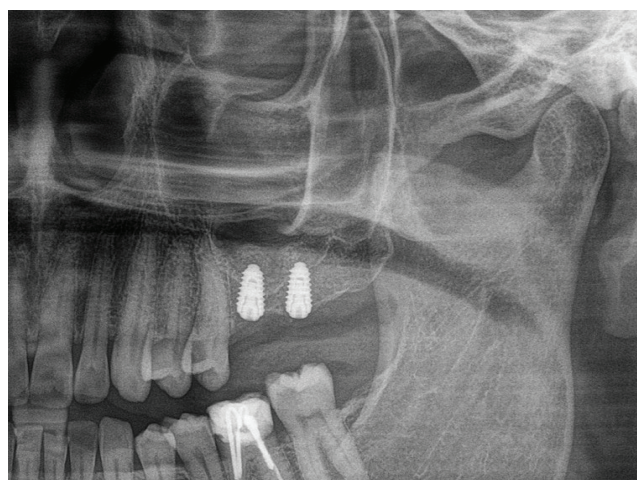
Panoramic x-ray after surgery
